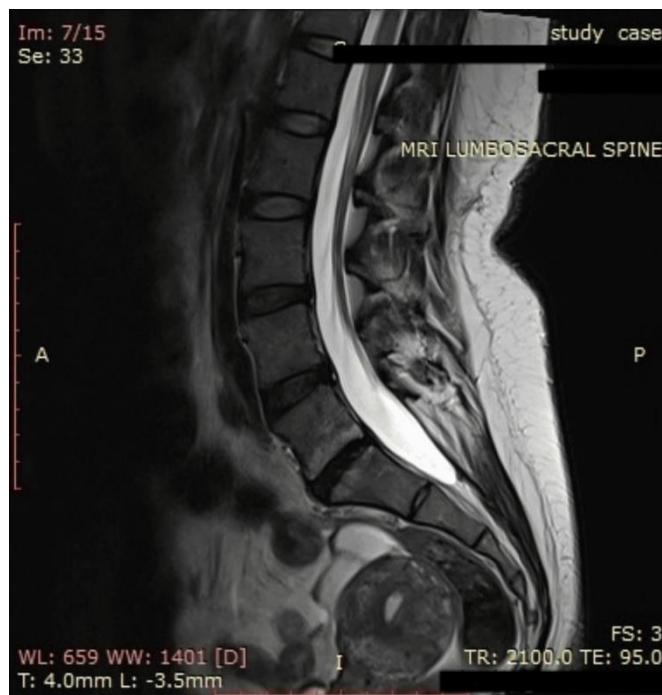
MRI Lumbosacral Spine T1. Minor posterior disc bulge at L4- L5, causing anterior thecal sac indentation and narrowing of the neural foramen.
